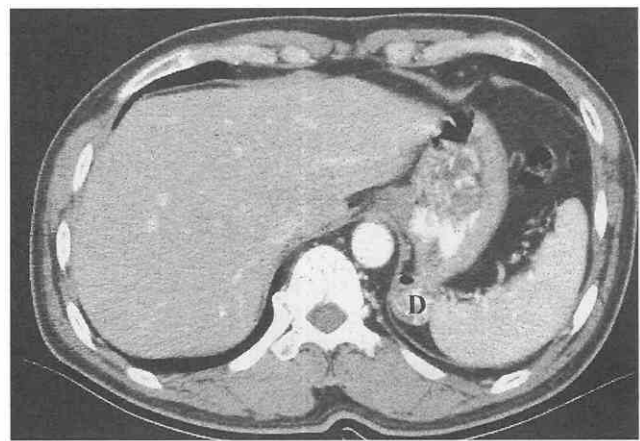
Gastric diverticulum. CT scan shows a diverticulum (D) arising from the posterior wall of gastric fundus, which is filled with oral contrast material and gas.
